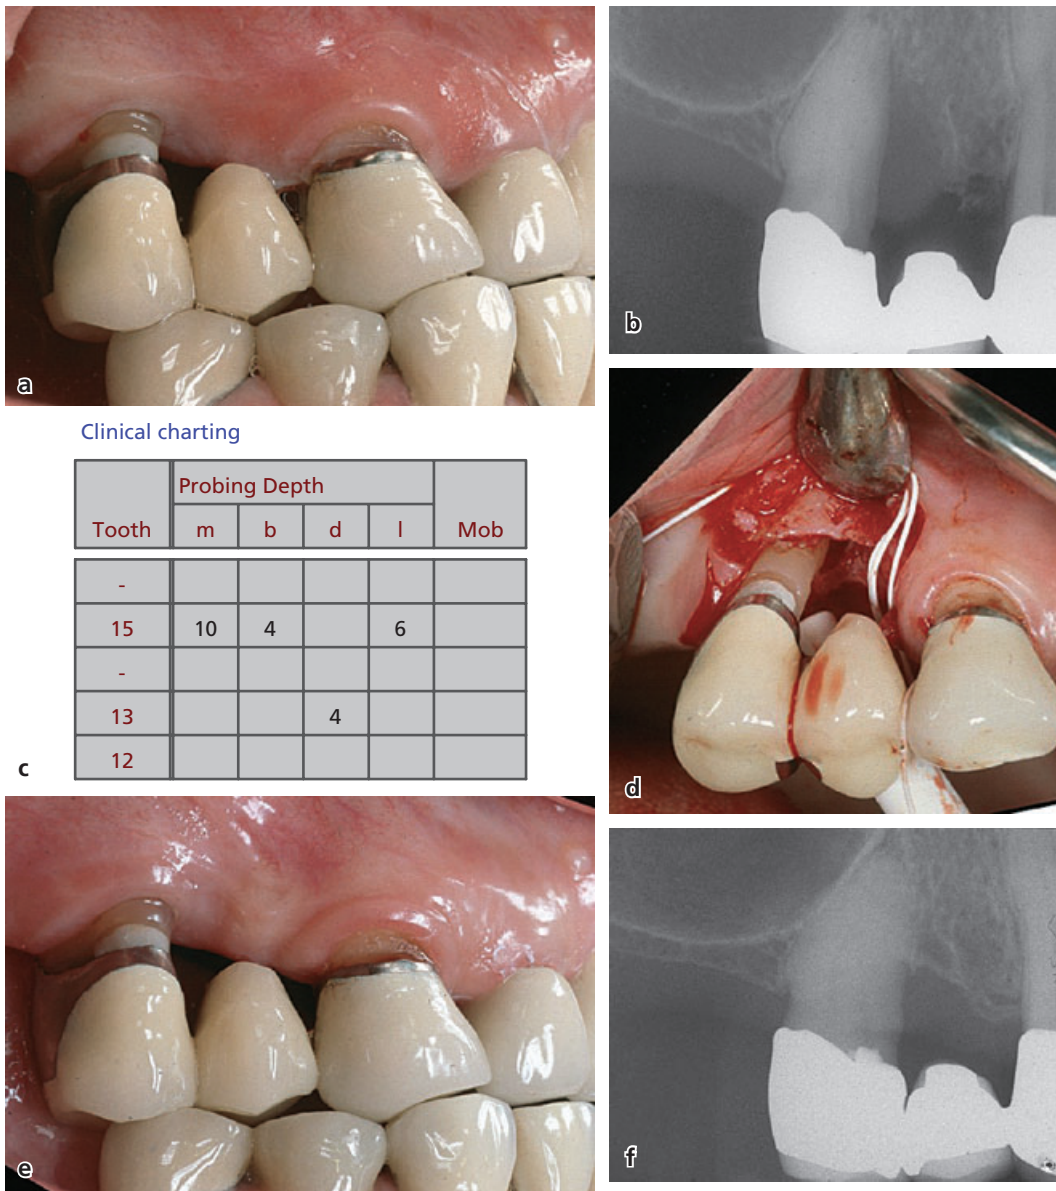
A 67-year-old female patient with a localized advanced periodontal defect at tooth 15. (a–c) Clinical and radiographic status at the initial examination. (d) Flap elevated and the morphology of the defect can be determined as a wide combined one-/two-/three-wall defect. (e,f) Clinical and radiographic status 6 years after active treatment. Courtesy of Dr. G. Heden, Sweden.
